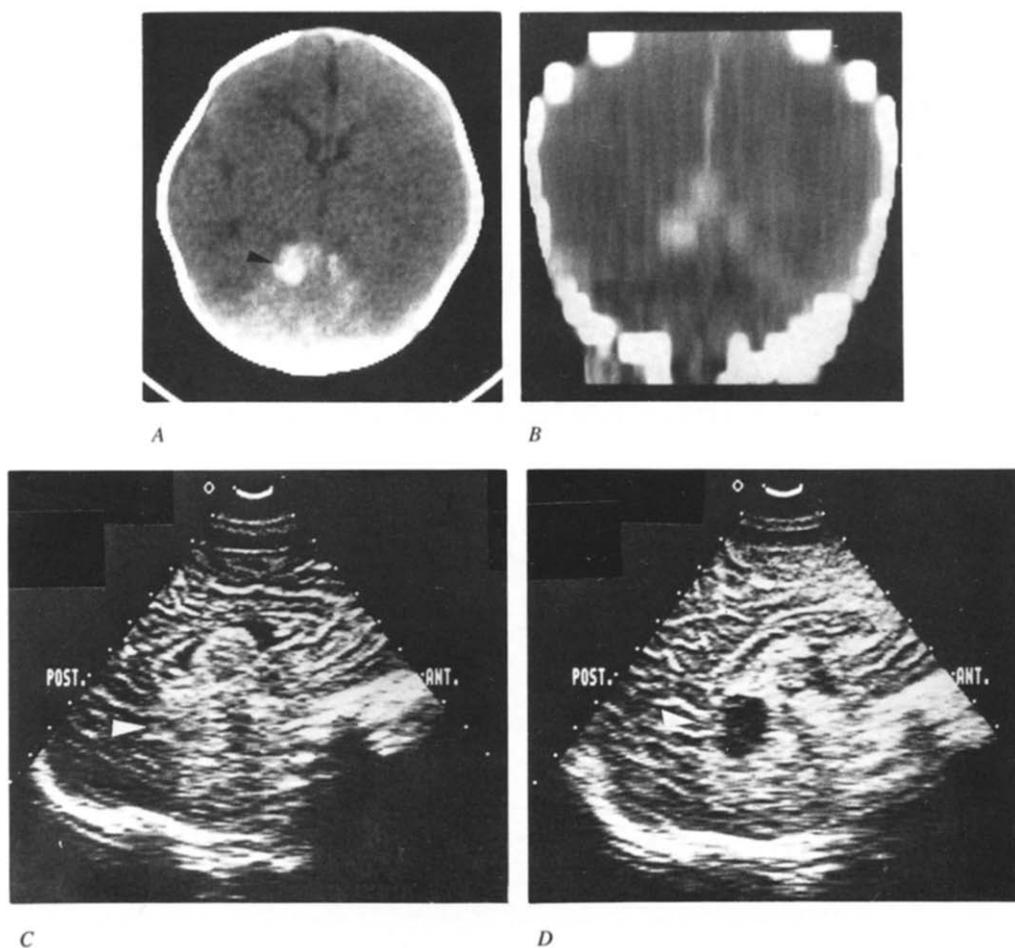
Tentorial subdural hemorrhage at the falcotentorial junction near the incisura area (Patient 1). (A) CT along the free margin of tentorium, demonstrating the blood accumulated at the quadrigeminal areas (arrowhead). (B) CT coronal reconstruction view disclosing the hemorrhage located at the falcotentorial junction. (C) Midsagittal US demonstrating an echogenic lesion at the quadrigeminal area (arrowhead) which downwardly displaces the cerebellar vermis. (D) Midsagittal US 7 days later revealing the previous echogenic hemorrhage resolved into an echolucent lesion (arrowhead).
